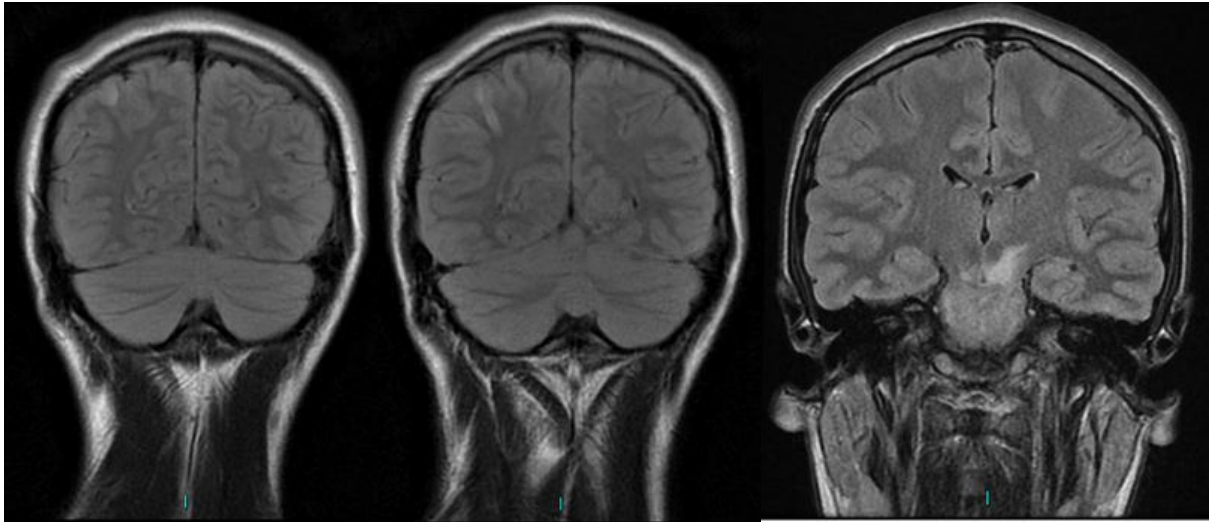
MAGNETIC RESONANCE IMAGING (MRI) OF THE BRAIN AND SPINAL CORD, CASES 1 AND 2
